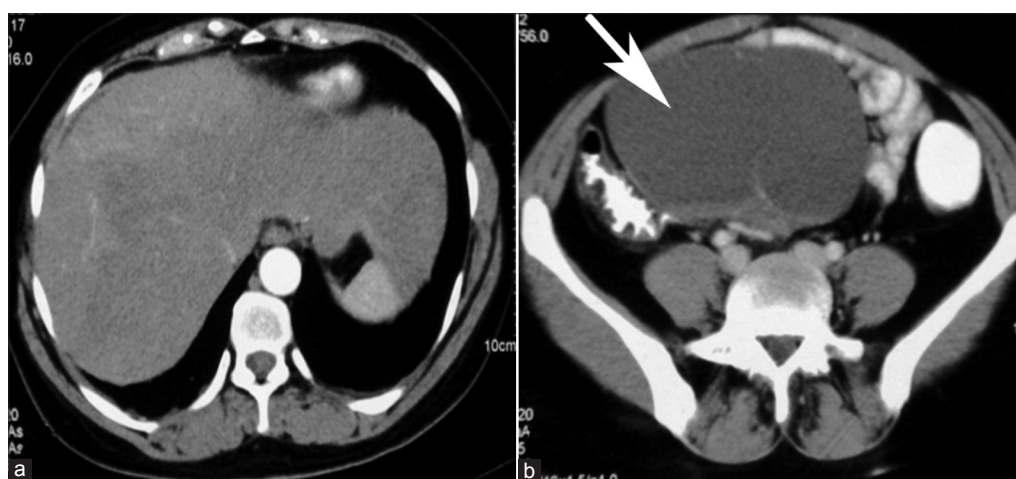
Axial views of computed tomography scan showing significant reduction in liver metastasis (a) and increase in size of ovarian metastasis (10 cm × 8 cm) (white arrow) (b)
